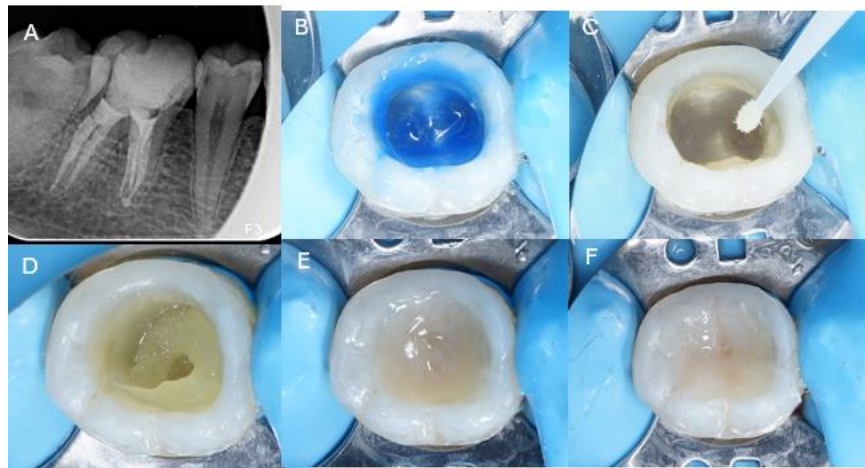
(A) During the third appointment, Postoperative radiographic evaluation demonstrated complete obturation of the root canal, with no abnormalities observed in the periapical region.
